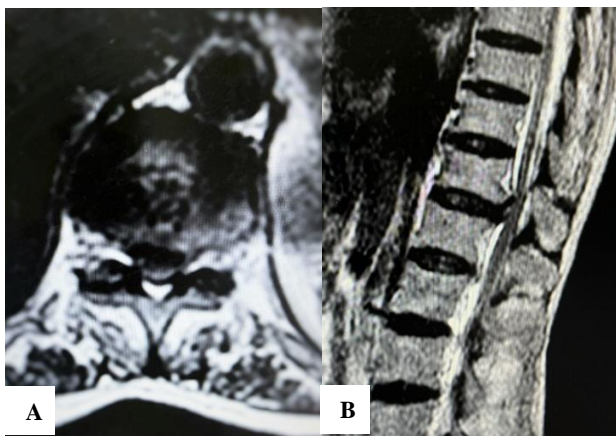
(A) Preopmri axial view, (B) preop MRI sagittal view.
